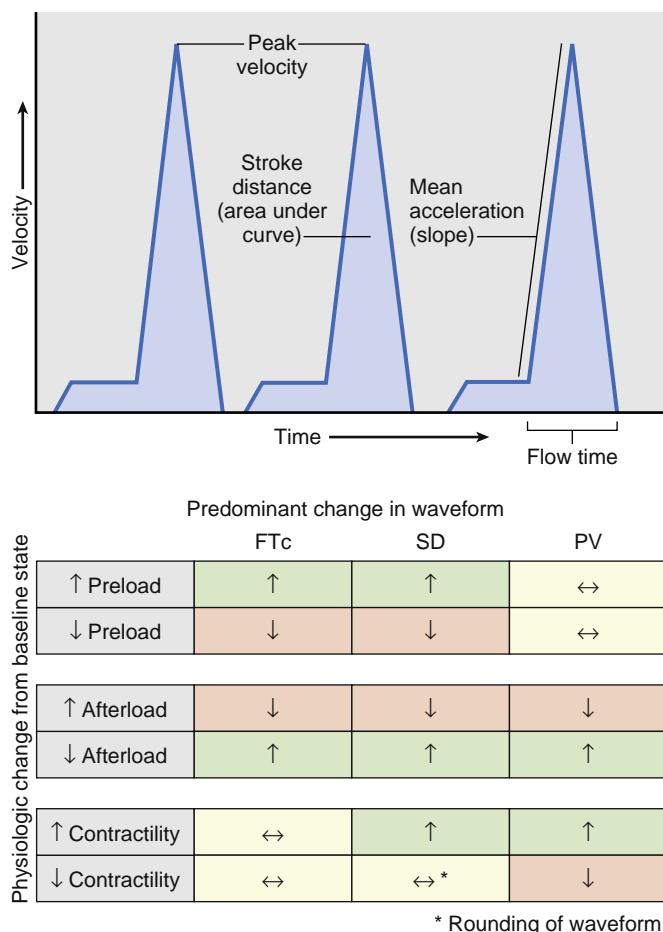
The velocity-time waveform displayed by esophageal Doppler cardiac output monitoring devices reflects alterations in contractility, preload, and afterload. Stroke distance (SD) is directly related to calculated stroke volume and provides a useful surrogate measure of cardiac output. FTc, Systolic flow time corrected for heart rate; PV, peak velocity.
